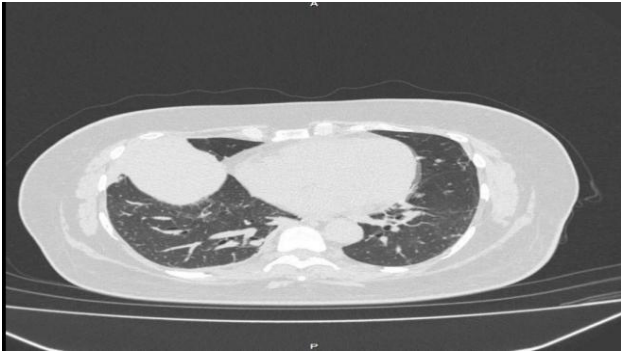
HRCT chest showing fluid bronchogram with linear branching hyperdense content in few of the dilated bronchi.
